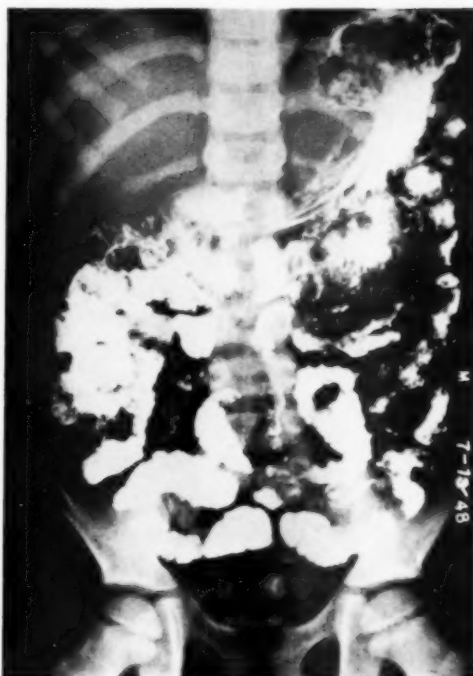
Case I. Roentgenogram made four hours after barium and water drink, showing gastric residue and abnormality of small intestine. The jejunal loops are narrowed and irregular in outline. Most of the mucosal folds are obliterated. The loops of ileum show dilatation and segmentation.
